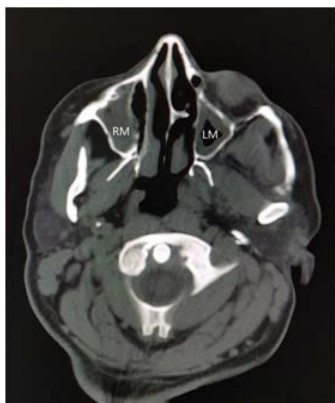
CT scan axial section showing complete opacification of the right maxillary sinus (RM) and mucosal thickening in the left maxillary sinus (LM) (22-year old female).
